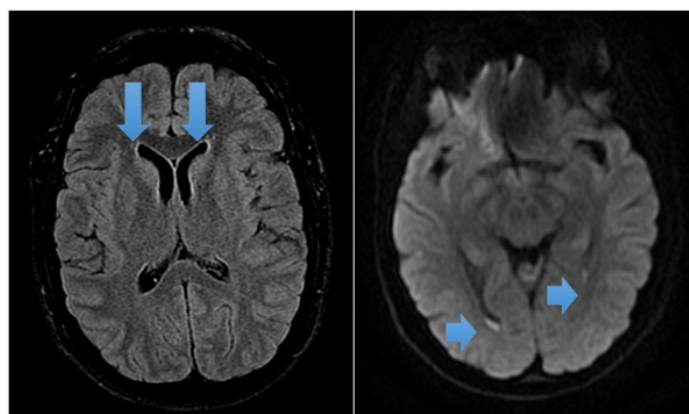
MRI brain performed on POD 4 within the dependent portion of the lateral ventricles, possibly representing early changes of ventriculitis/meningitis
